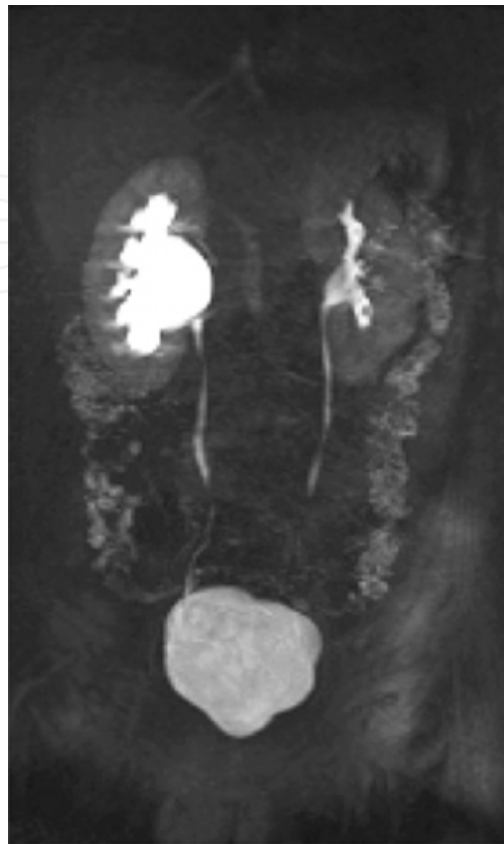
Hydronephrosis in the right kidney with ureteropelvic junction obstruction by Uro MRI.
